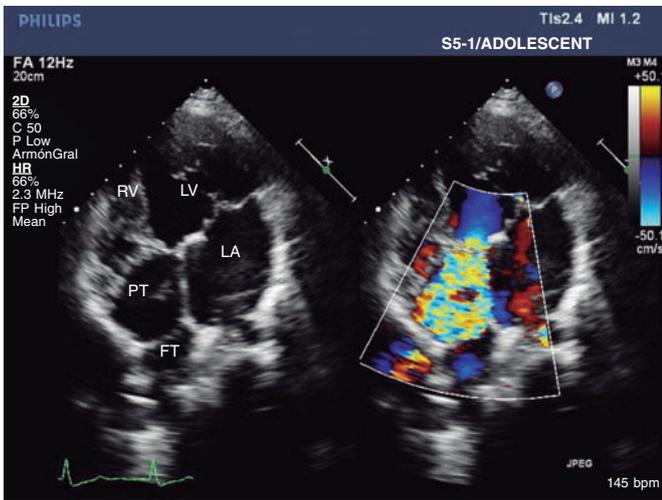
Echocardiographic apical four-chamber view showing the origin of turbulent flow in the subpulmonary region until the roof of pulmonary trunk. FT, Fontan tube; LA, left atrium; LV, left ventricle; PT, pulmonary trunk; RV, right ventricle.
